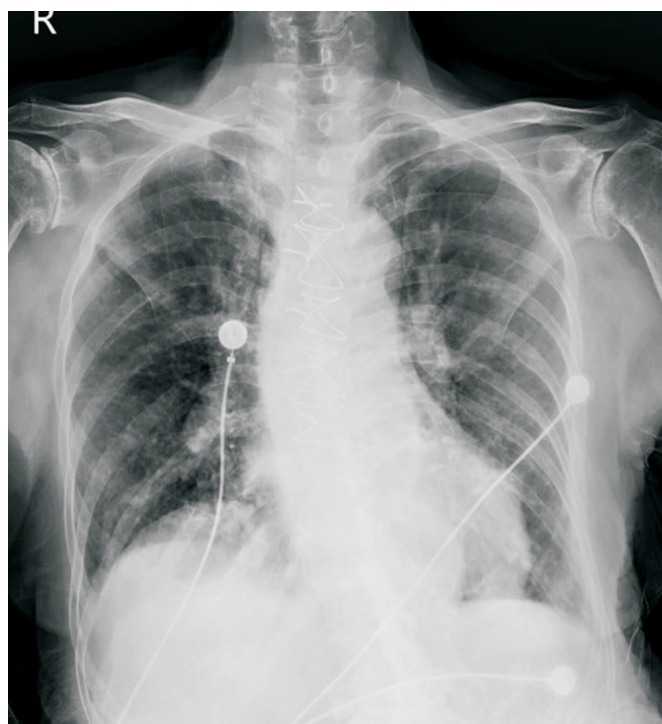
The anterior-posterior view chest X-ray image on admission, which revealed no active lung lesion or cardiomegaly.
